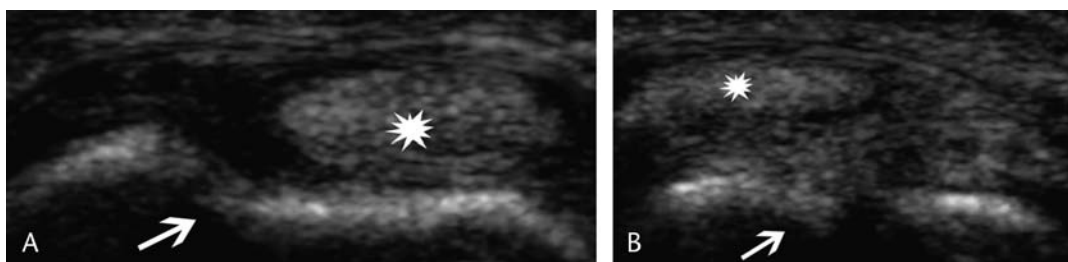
A, Preoperative short axis ultrasound image performed with the wrist in neutral position shows the ECU tendon (star) within the shallow ulnar groove (arrow). B, Preoperative short axis ultrasound image performed with the wrist in supination shows medial subluxation of the tendon (star) out of the groove (arrow).
